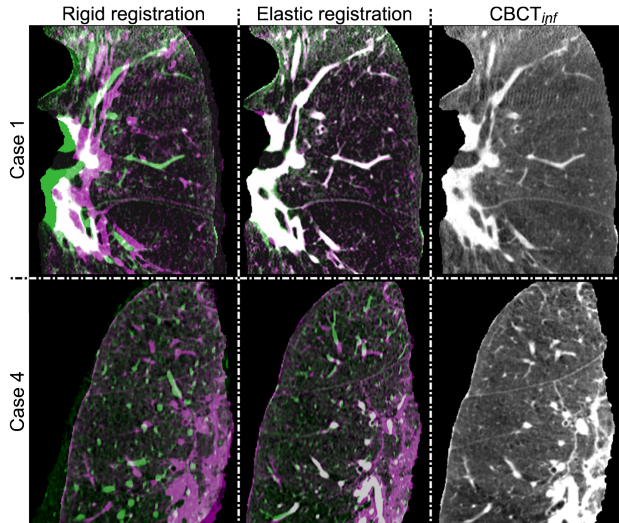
Qualitative results of rigid and elastic registration between the preoperative CT (green) and intraoperative CBCT<sub>inf</sub> (magenta) images. Coronal slices are shown for two representative cases. The target CBCT<sub>inf</sub> image in gray-scale is shown in the far right column.
